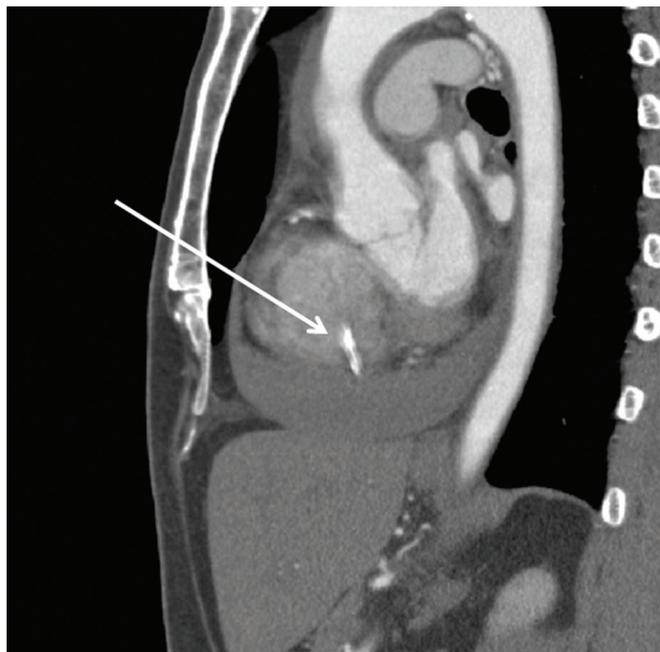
Sagittal view of contrast-enhanced computed tomography demonstrating linear opacity (arrow). The lower end of linear opacity appeared to be penetrating the right ventricular wall.
